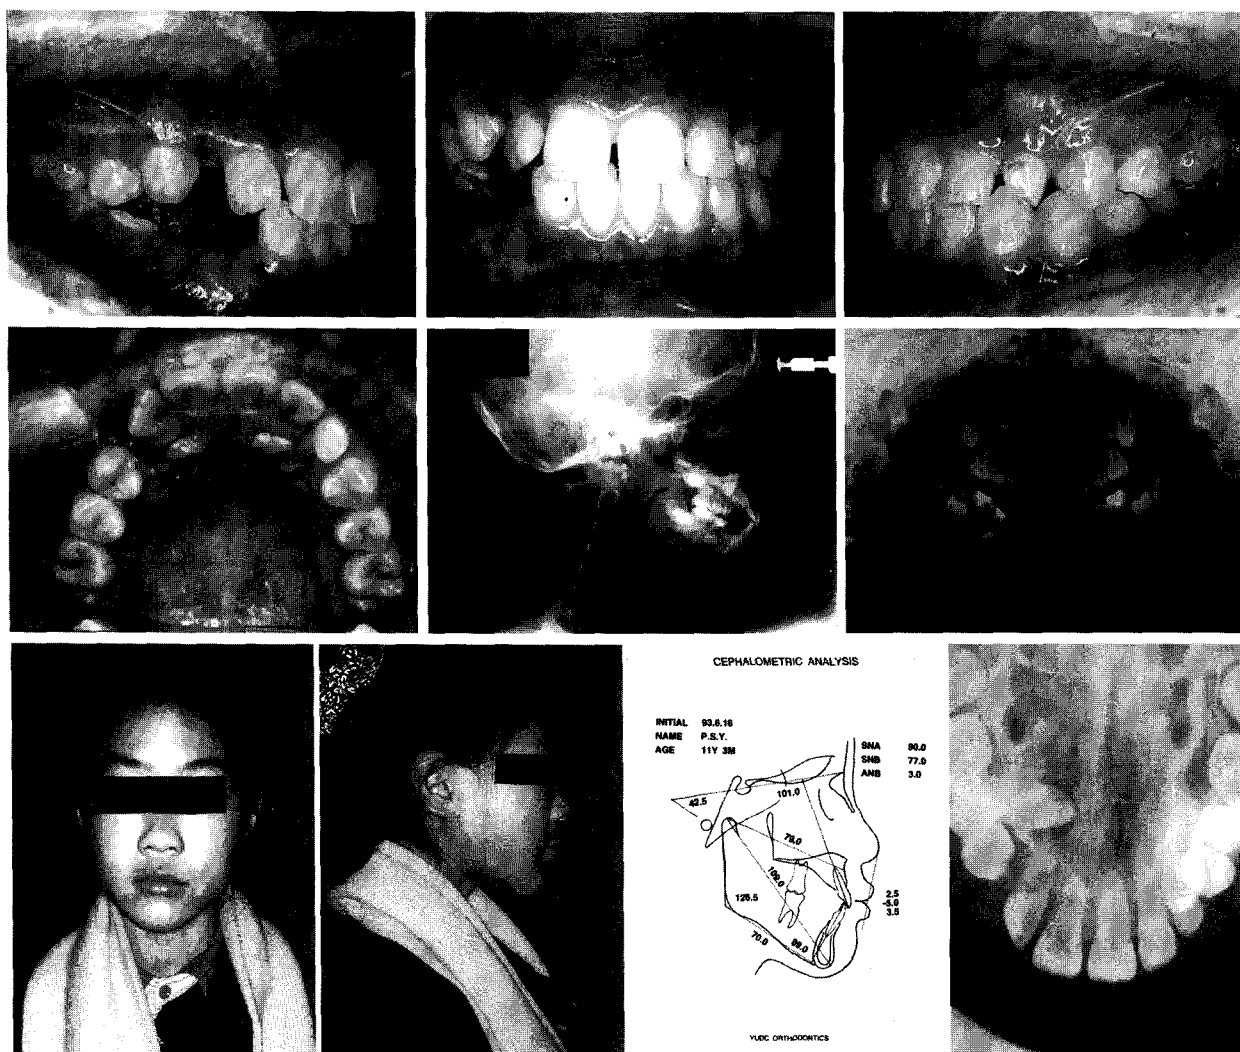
Case 1. Initial intraoral photos, facial photos, lateral cephalogram, orthopantomogram, occlusal X-ray, and cephalometric tracing
